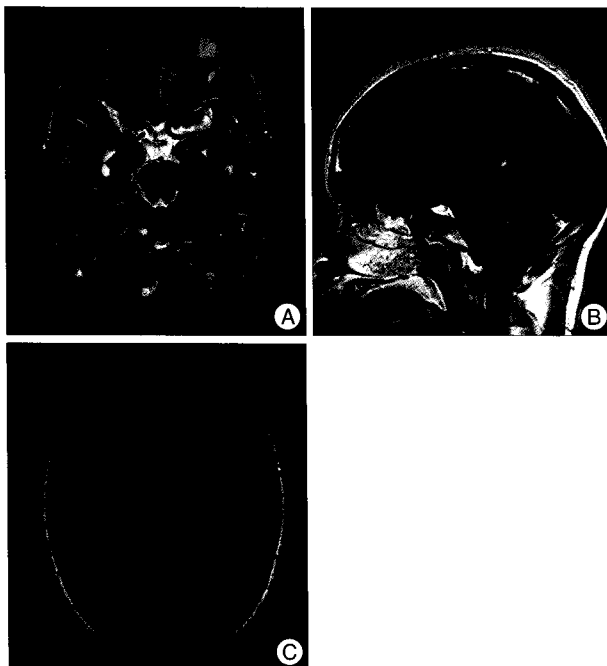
Brain MRI at admission. A : Brain axial, T2-weighted MR image without gadolinium shows that the numerous hyperintense cysts are in brain parenchyma, left optic lesion and temporalis muscle. B : Brain sagittal, post-gadolinium MR image reveals eccentric cyst in the tongue. C : Brain axial, T1-weighted MR image shows innumerable cysts with hyperintense eccentric lesions in the brain parenchyma.
